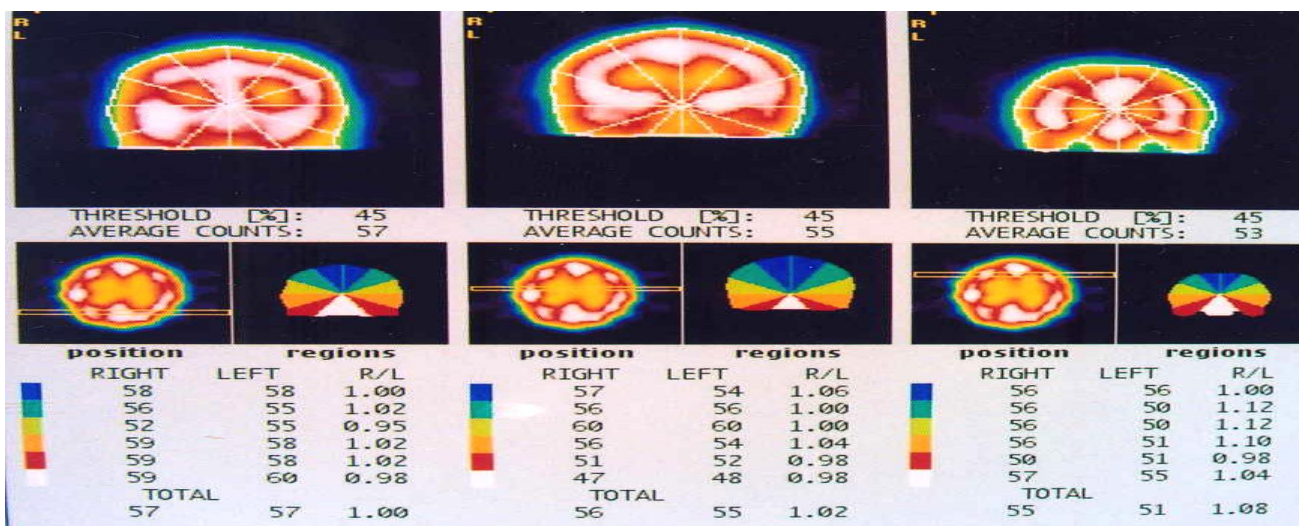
SPECT scan of patient of dissociative Amnesia
